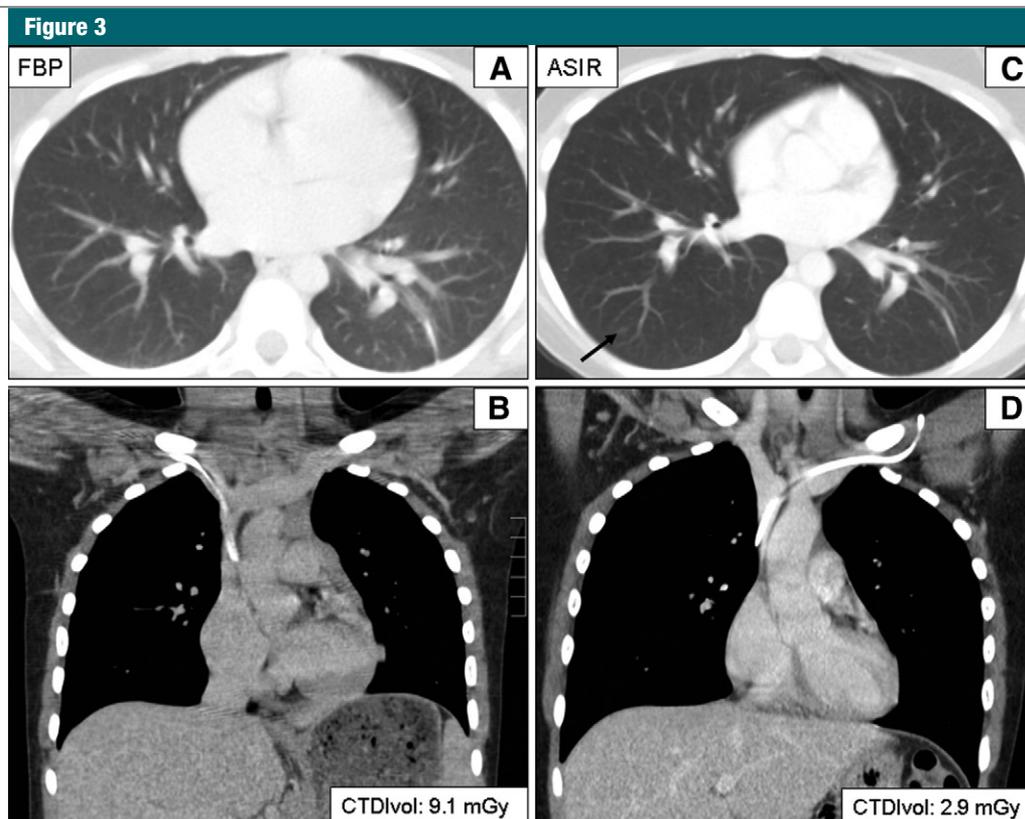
Chest CT images in a 10-year-old girl (weight, 37 kg; green zone) with a known history of rhabdomyosarcoma. *A*, Transverse and, *B*, coronal images reconstructed with FBP (9.1 mGy, 88 mA, 120 kVp). Follow-up, *C*, transverse and, *D*, coronal images reconstructed with ASIR (2.9 mGy, 55 mA, 120 kVp) show ill-defined ground-glass opacity (arrow) and resulted in 68% CTDI_{vol} reduction when compared with prior FBP images.
